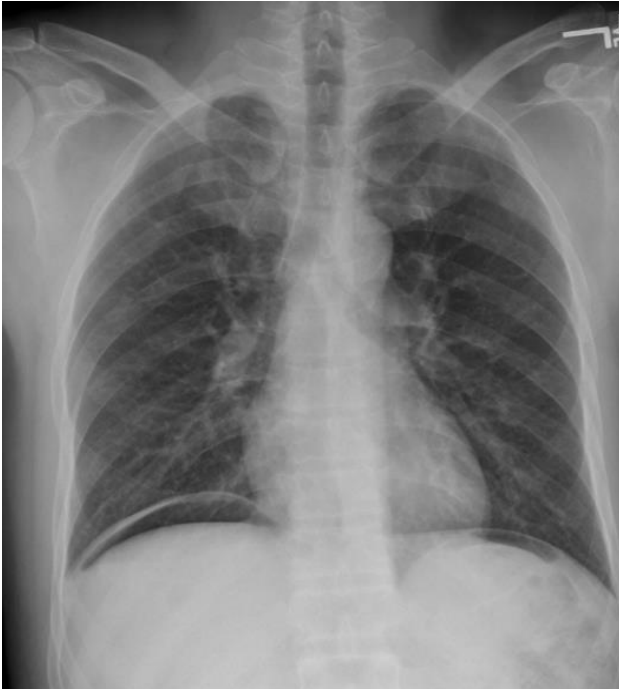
Chest X-ray showing air under the right hemidiaphragm.
